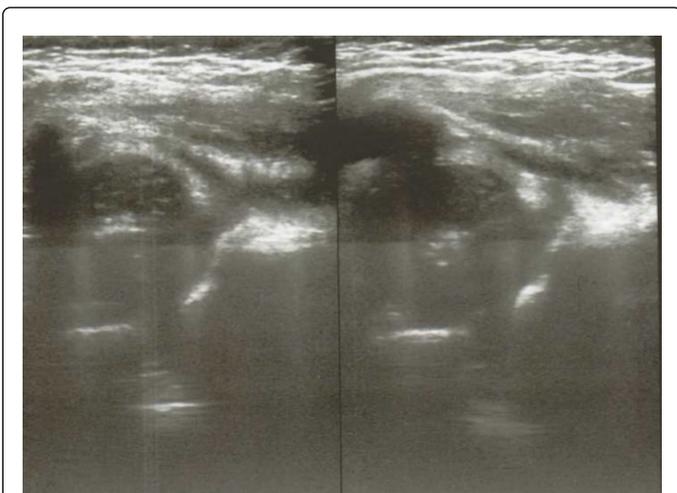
Simon's ultrasound examination prior to initiation of therapy at day 47 of the patient's life. Left and right hip in Graf's scale were rated as IIa with restriction of abduction in the right hip. The study was conducted on 25.11.2014.
